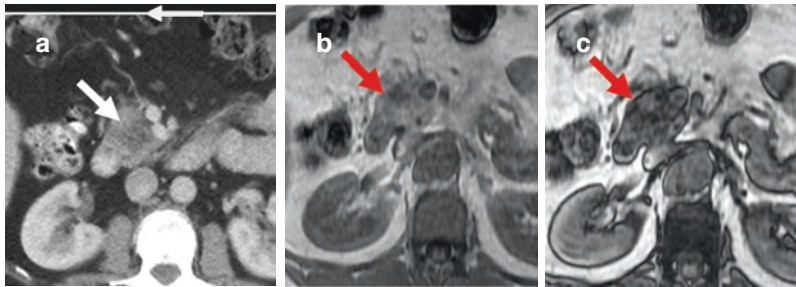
Characterization of pancreatic focal fatty infiltration mimicking as lesion on MDCT. (a) Portal venous phase axial MDCT image at the level of pancreatic head shows indeterminate low attenuation lesion (white arrow). (b, c) Axial T1-weighted in-phase (b) and out-of-phase
